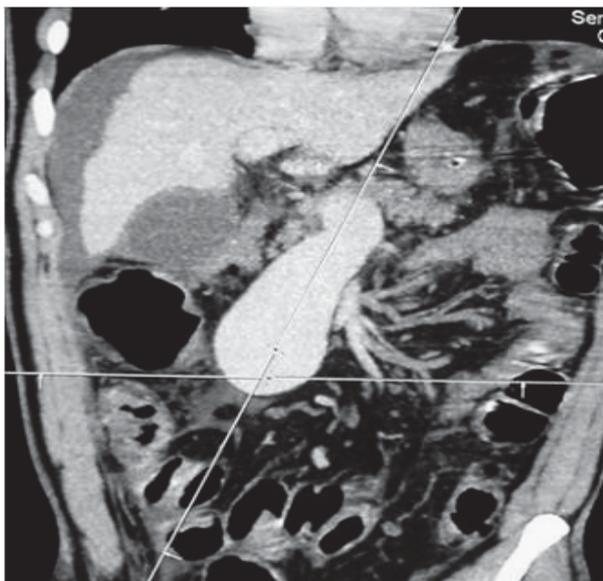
Computed tomography showed dilatation of the superior mesenteric vein
